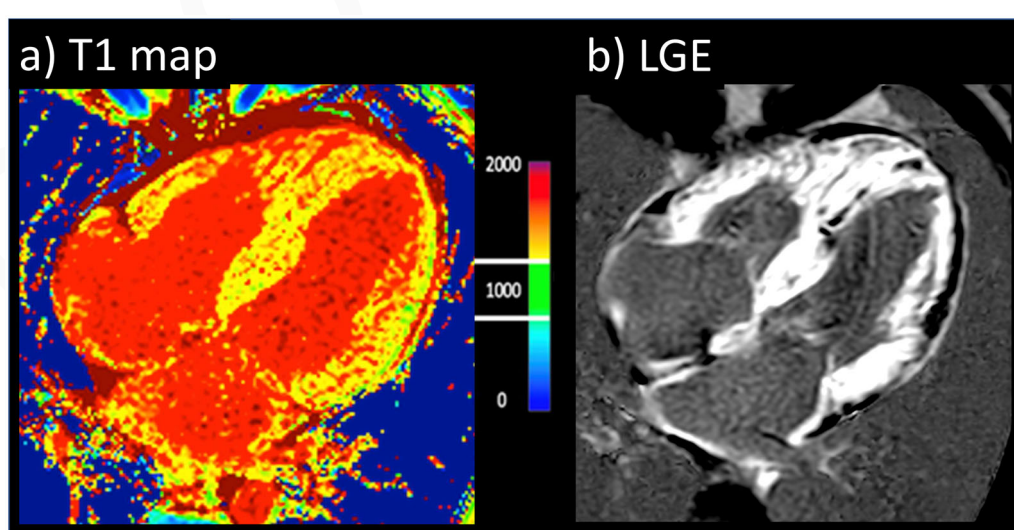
Example of a Class I indication of cMR: characterisation of infiltrative disease. 58-year-old man, with recently discovered hypertrophic cardiomyopathy complaining about chest-pain and dyspnoea. cMR showed markedly increased native T1 (1462 ms) on T1 mapping and diffuse LGE compatible with amyloidosis. ATTR amyloidosis was subsequently confirmed by absence of para-protein and positive DPD scintigraphy.
